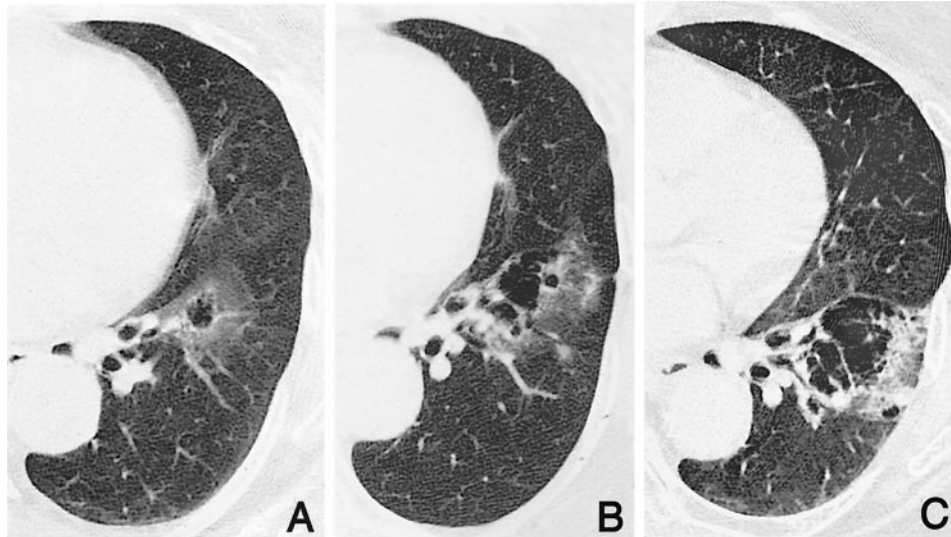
Chest computed tomograms (A: August 2000, B: November 2001, C: September 2002) reveal that a solitary cystic lesion surrounded by ground-glass opacities in the left lower lobe enlarged and became multiloculated over a 2-year period.
